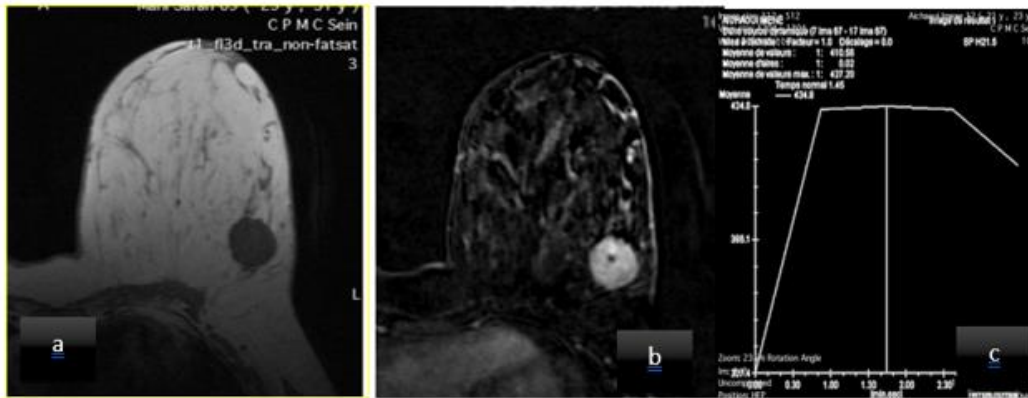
MRI aspect, T1 sequence (a), sequence with contrast injection (b), sequence in subtraction showing a unilocal mass at the level of the upper outer quadrant of the left breast, rounded shape, with regular contours, in T1 hyposignal, heterogeneously enhancing after contrast injection, producing a type 3 hemodynamic curve, classifying the lesion as BI-RADS 6 by ACR
